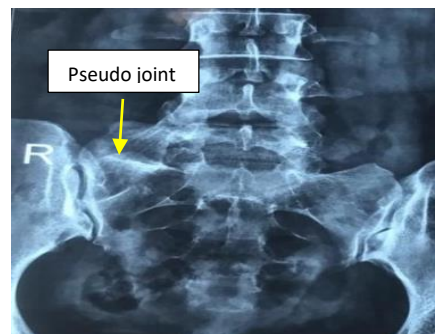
X-ray lumbosacral spine showing pseudo joint on right side (case 2)
